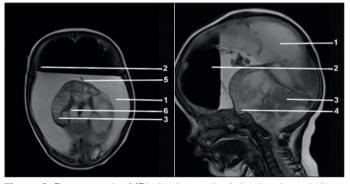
Post-operative MRI after inserted subdural peritoneal shunt (1- subdural hematoma 2-remaining space after hematoma drainage 3-cortex 4-diencephalon 5- proximal catheter of subdural peritoneal shunt 6-ventricle).
